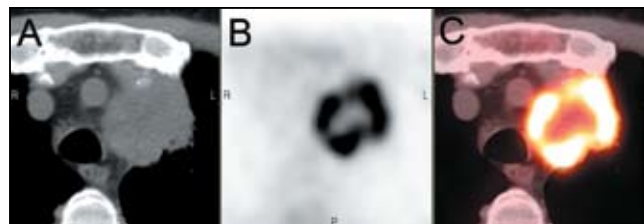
Axial CT (A), PET (B), and fused PET/CT (C) images show intense uptake around the periphery of the left upper lobe mass. The central region of the mass was photopenic consistent with central necrosis.
